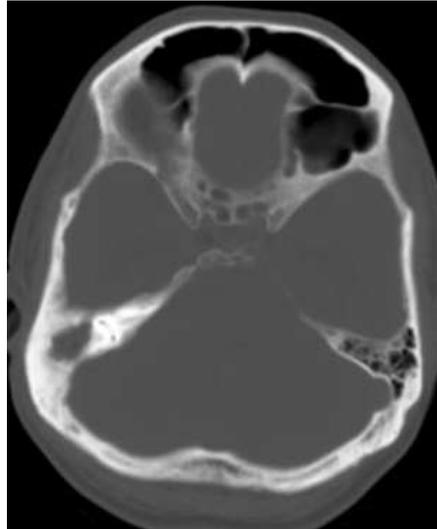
Axial CT bone window- Soft tissue mass filling mastoid antrum with erosion of bone and ossicles.
